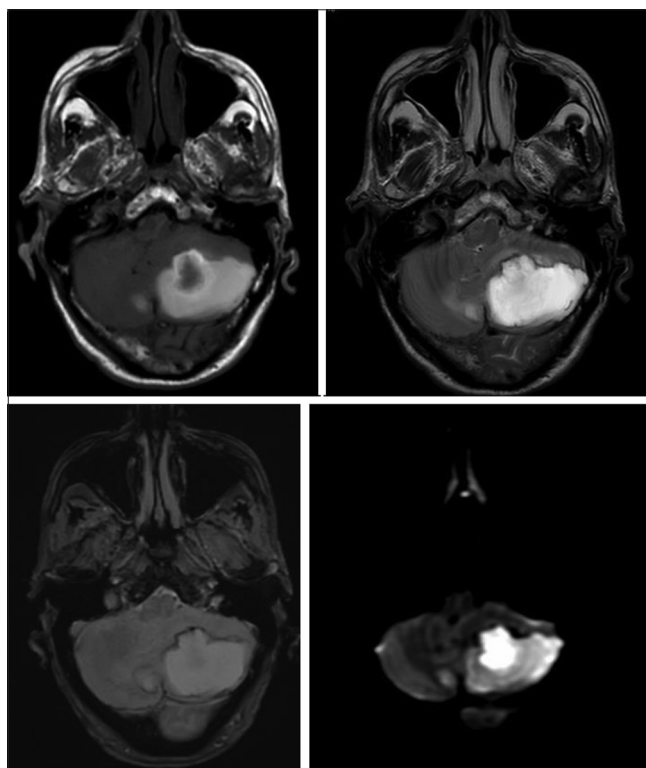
Axial FLAIR, T1, SWI and diffusion weighted MR images showing a large hyperintense lesion in the left cerebellar hemisphere with blooming on SWI and areas of restricted diffusion on DWI images, which is suggestive of subacute cerebellar hemorrhage
